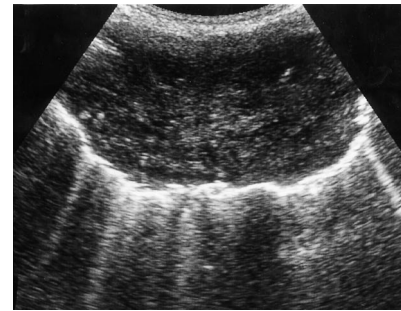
Ultrasound chest: typical appearances of carcinoma, as an irregular mass and central necrotic cavitation.
